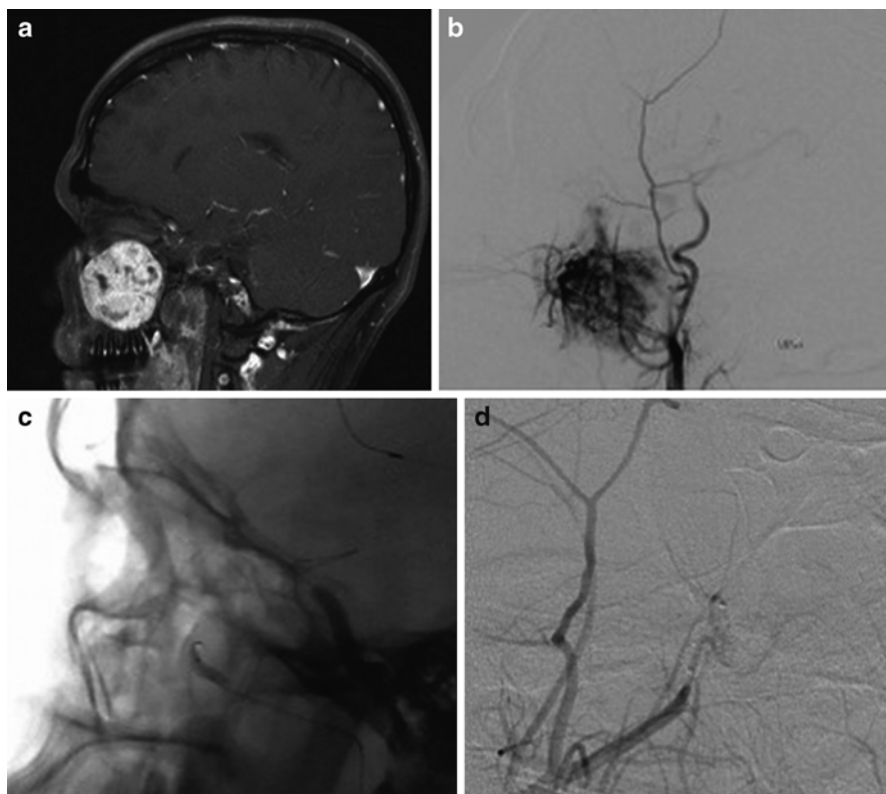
Gadolinium-enhanced sagittal MRI showing avid enhancement of a maxillary sinus juvenile nasal angiofibroma (a). Microcatheter injection of the internal maxillary artery demonstrates significant tumor blush (b) that was treated with particle embolization (c), resulting in elimination of the previously seen blush (d)
